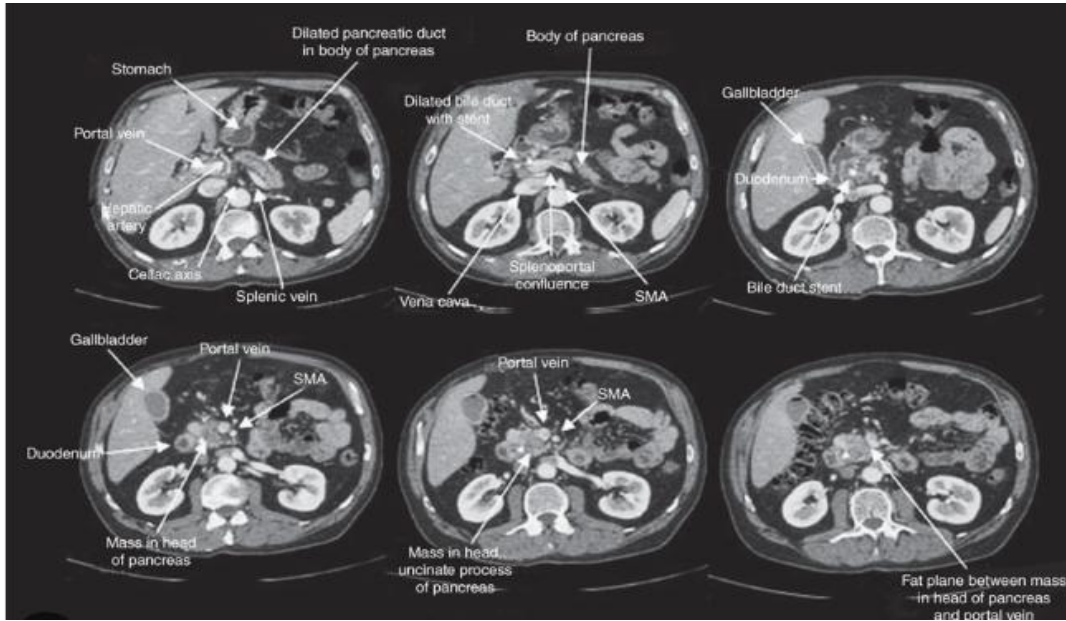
Example of PC based CT Images
